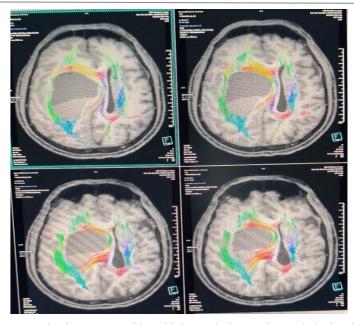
These MRI DTI tractography images provide a high-resolution, color-coded visualization of white matter fiber tracts in the brain. They are likely used in the context of neurological assessment, pre-surgical planning, or research into brain connectivity. The colored fibers indicate orientation-specific pathways critical for motor, cognitive, and sensory functions.
